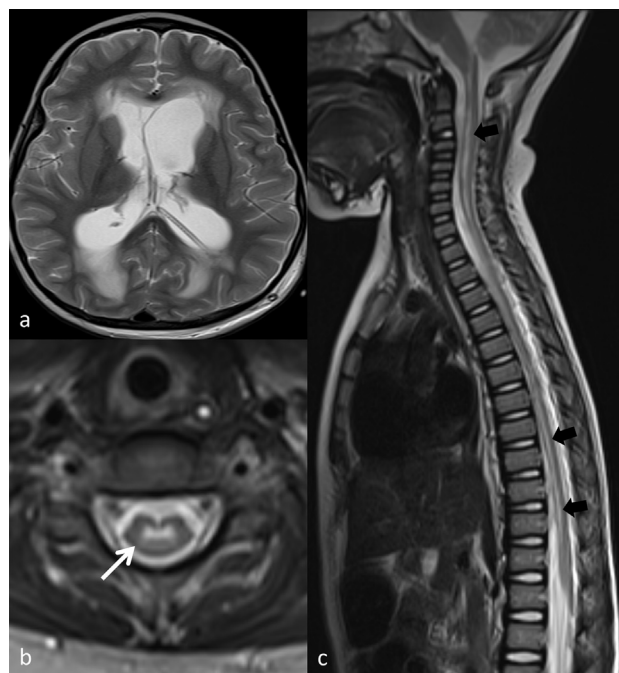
Magnetic resonance imaging findings. 1a: Axial T2-weighted brain imaging depicting hydrocephalus and a left trans-parietal ventriculoperitoneal shunt. 1b: Axial T2-weighted spinal cord imaging. An ‘M-shaped’ grey matter abnormal signal enhancement is shown (white arrow), suggestive of selective grey matter involvement. 1c: Sagittal T2-weighted spinal cord imaging, demonstrating the extensive, selective (non-enhancing) whole cord grey matter signal changes (black arrows).
